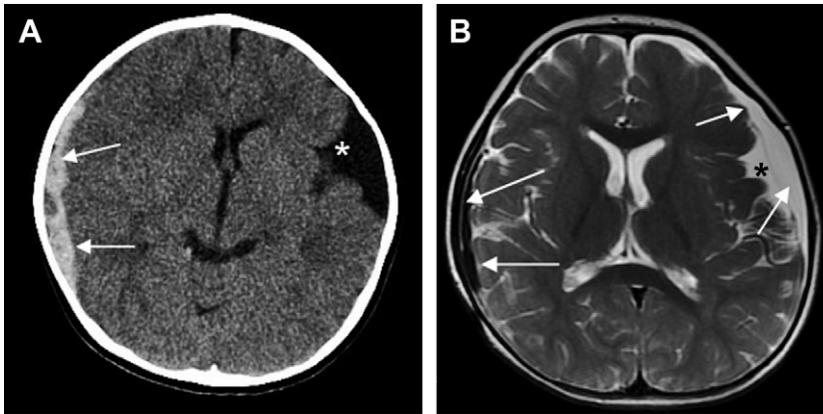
Sixteen-month-old with triad (right RH) and alleged NAI; also, short-distance fall with right scalp impact. CT (A) shows left sylvian arachnoid cyst (*) and right hyperacute SDH (arrows). T2 MR imaging (B) 2 days later shows acute right SDH (long arrows) and smaller left sylvian arachnoid cyst (*) with subdural hygroma (short arrows).
